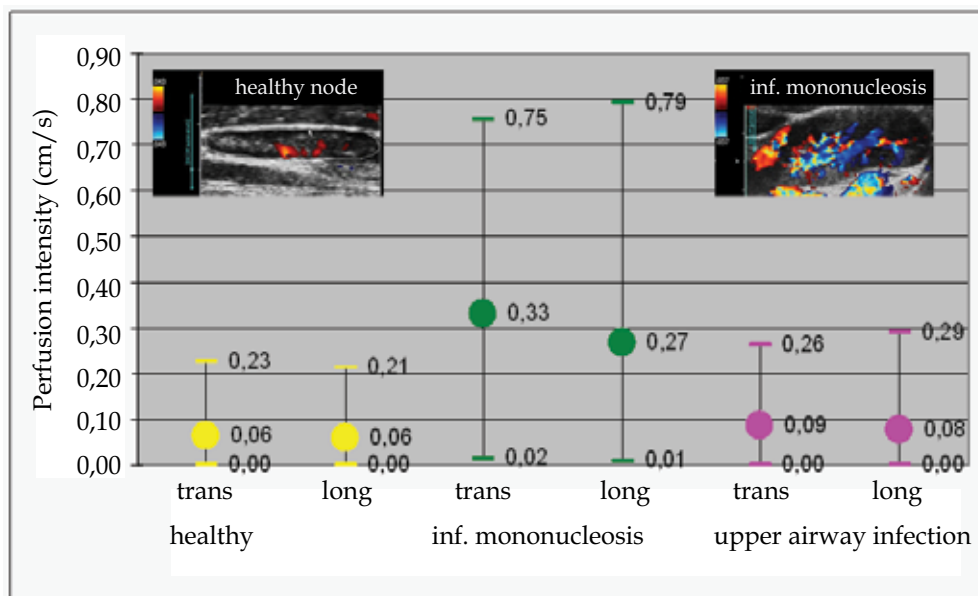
Lymph node perfusion as seen in DTPM: no differences exist between longitudinal (long) and transverse (trans) sections of the nodes. Infectious mononucleosis raises cervical node perfusion significantly (green symbols) compared to nodes from healthy probands (yellow) in contrast to nodes in acute upper airway infections (pink). Insets: left: normal node in color Doppler Right: Node in infectious mononucleosis (EBV-infection)
